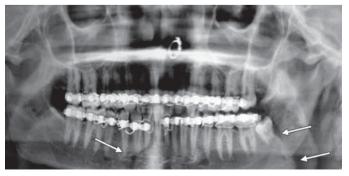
Orthopantomograph (OPG) showing fracture right parasymphysis and displaced angle of mandible left side.
